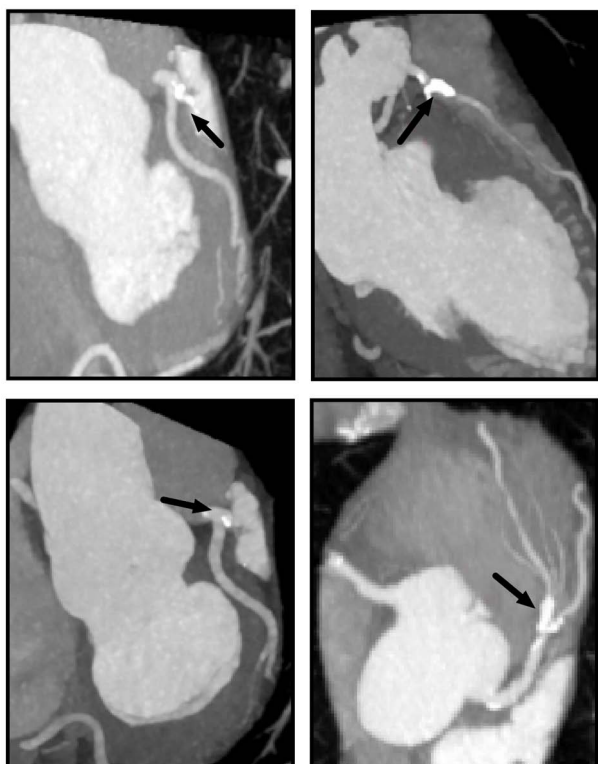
Confirmation of atherosclerosis diagnosis in different patients using computed tomography coronary angiography in the coronary artery. Arrows indicate the location of the atheromatous plaque. Magnification, x50.
